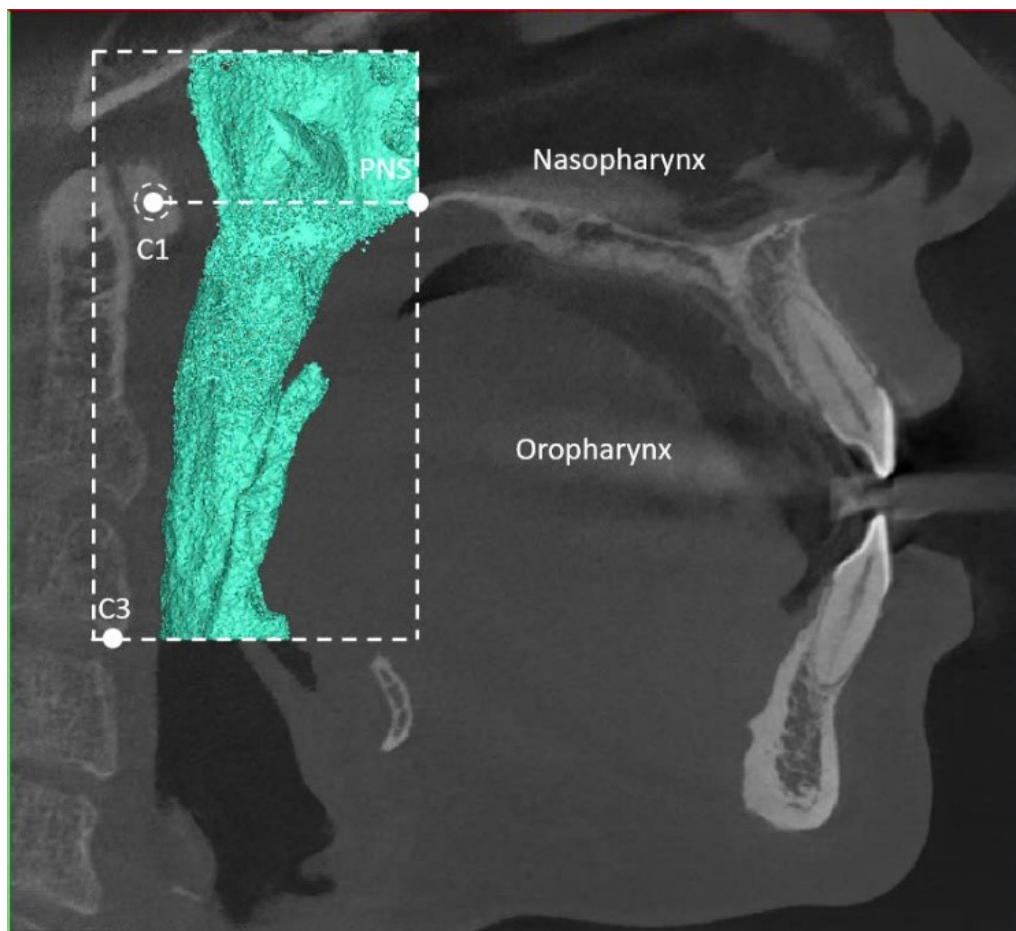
3D image of the pharyngeal airway on CBCT. The region superior to the plane passes through the two points of the PNS on both sides and the first cervical vertebra (C1). The region inferior to the plane passes through the two points of the PNS on both sides and the first cervical vertebra (C1).
